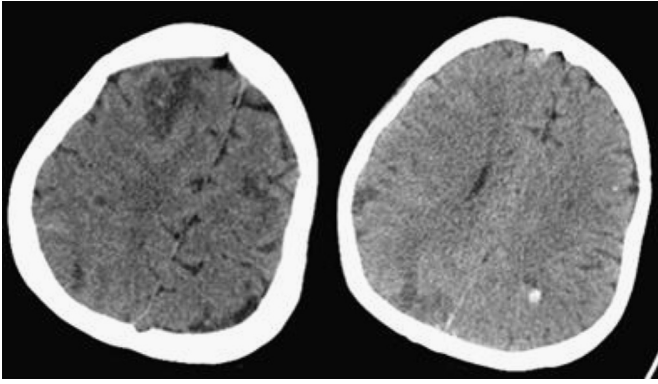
Follow-up CT on the 4th day of admission showed irregular hyperdense lesions within the low density of right frontal and bilateral occipital lobes, indicating hemorrhage.
